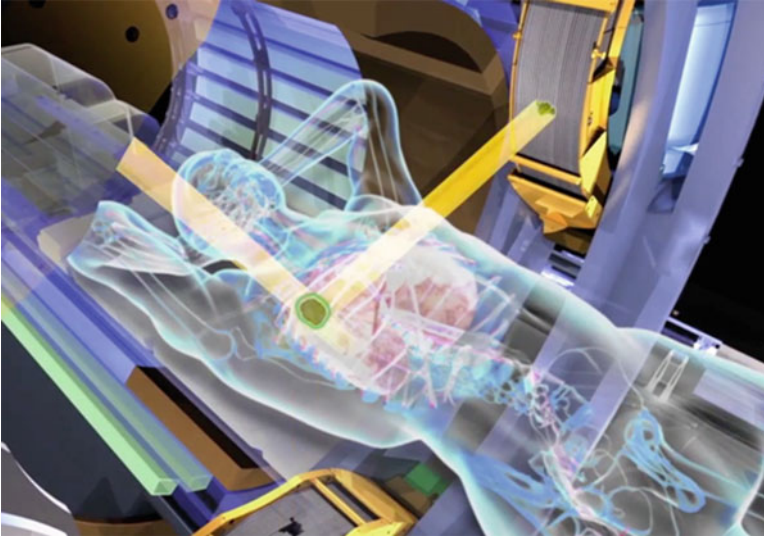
Treatment by the MRI-based cobalt machine (Courtesy of Ref. 13)
